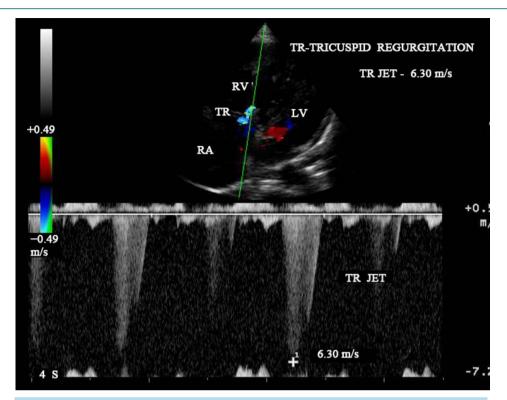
Apical 4 chamber view—CW doppler showing high velocity TR (tricuspid regurgitation) jet with early peaking suggesting high RV pressure at suprasystemic levels—165 mmHg.
